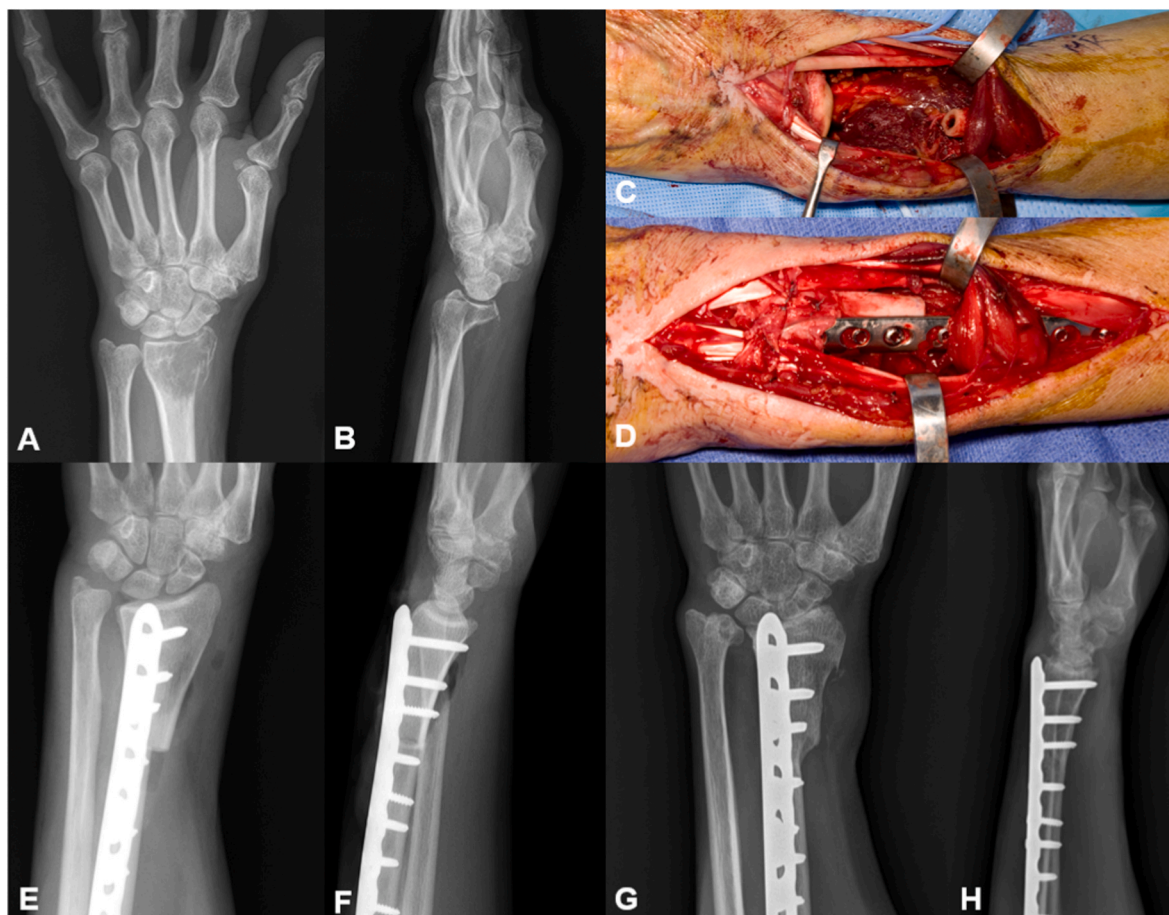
AP (A) and lateral (B) radiographs of a Campanacci Grade 3 GCT which was treated with resection (C) and osteoarticular allograft reconstruction with compression plate fixation (D). Immediate post-operative radiographs show sparing and reconstruction of the radiocarpal joint (E, F). Four-year post-operative radiographs show solid fusion but also radiocarpal degenerative changes (G, H).
